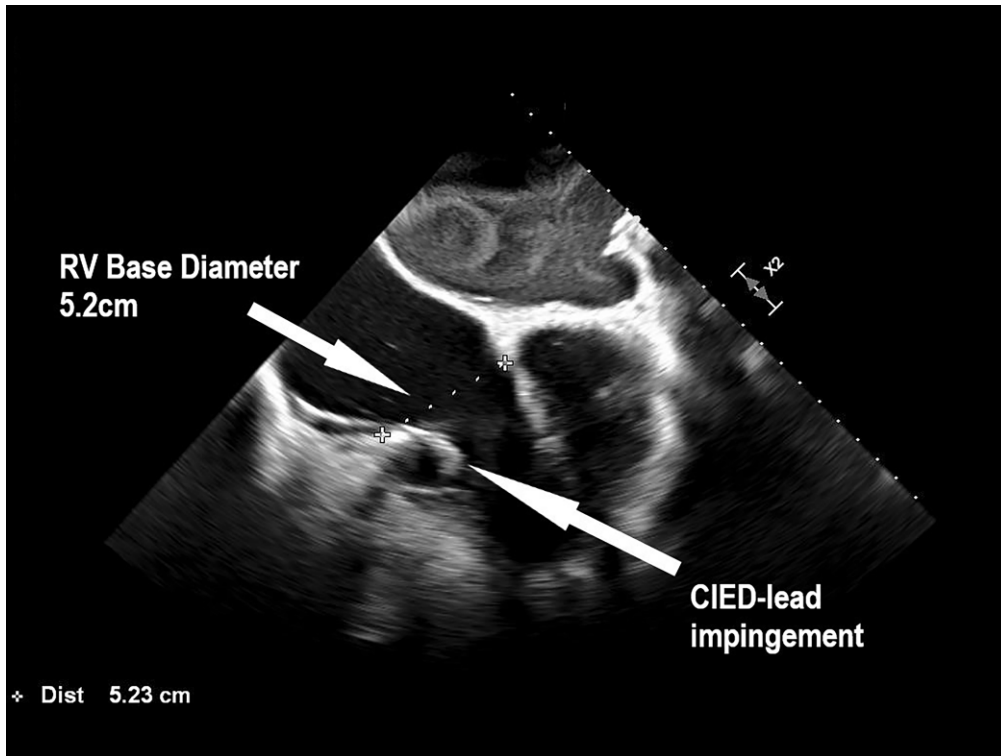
Transoesophageal echocardiogram showing a dilated right ventricle.
